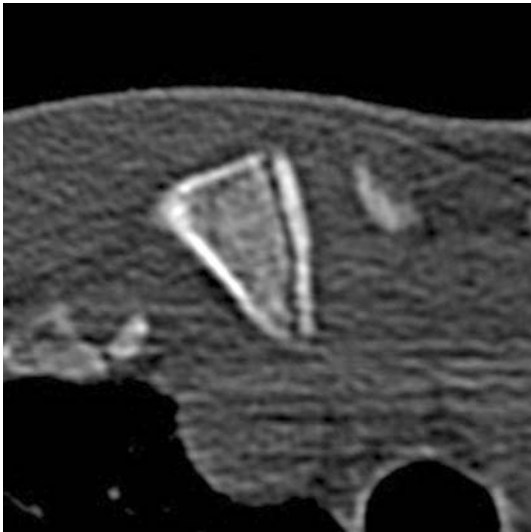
CT scan of the medial epiphyseal cartilage of the right clavicle (detail) of the Vietnamese male; ossification stage 2
